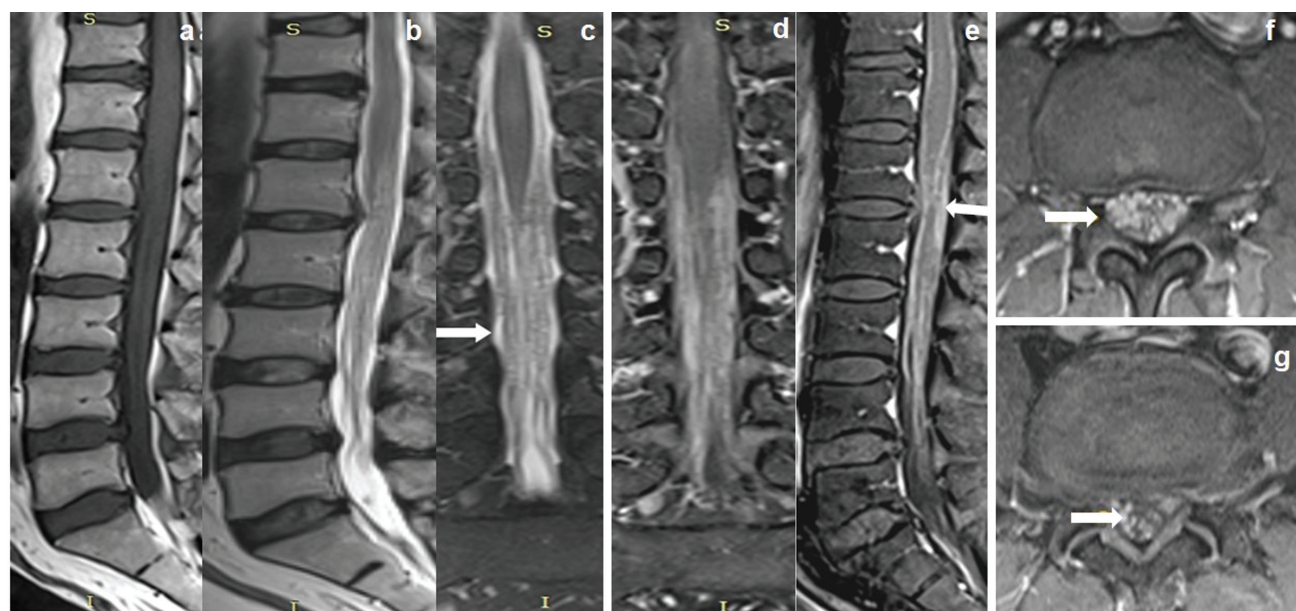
A 53-year-old male patient with a diffuse pattern of primary lymphoma presented with chronic low backache with radicular pain and paraparesis. Sagittal T1-weighted (T1W), T2W, and coronal short tau inversion recovery images (A–C) showed ill-defined T1W isointense and T2 hypo to isointense sheet-like lesions seen in the intradural location from D12 to L5 vertebral level with inferior extension along the cauda equina fibers (arrow). Coronal, sagittal, and axial postgadolinium T1W images (D–G) showed sheet-like homogenous enhancement over the conus medullaris and along the cauda equina fibers (arrows).
